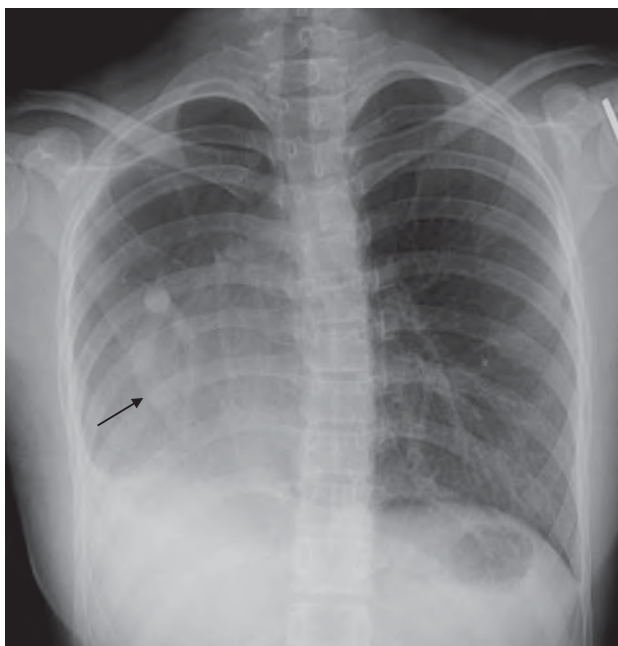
Frontal radiograph of the chest in an asymptomatic patient shows a curvilinear vein coursing anteromedially towards the inferior vena cava (black arrow). This was a partial anomalous venous return. Also notice the rightward mediastinal shift caused by hypoplasia of the right lung consistent with hypogenetic lung syndrome or scimitar syndrome.
